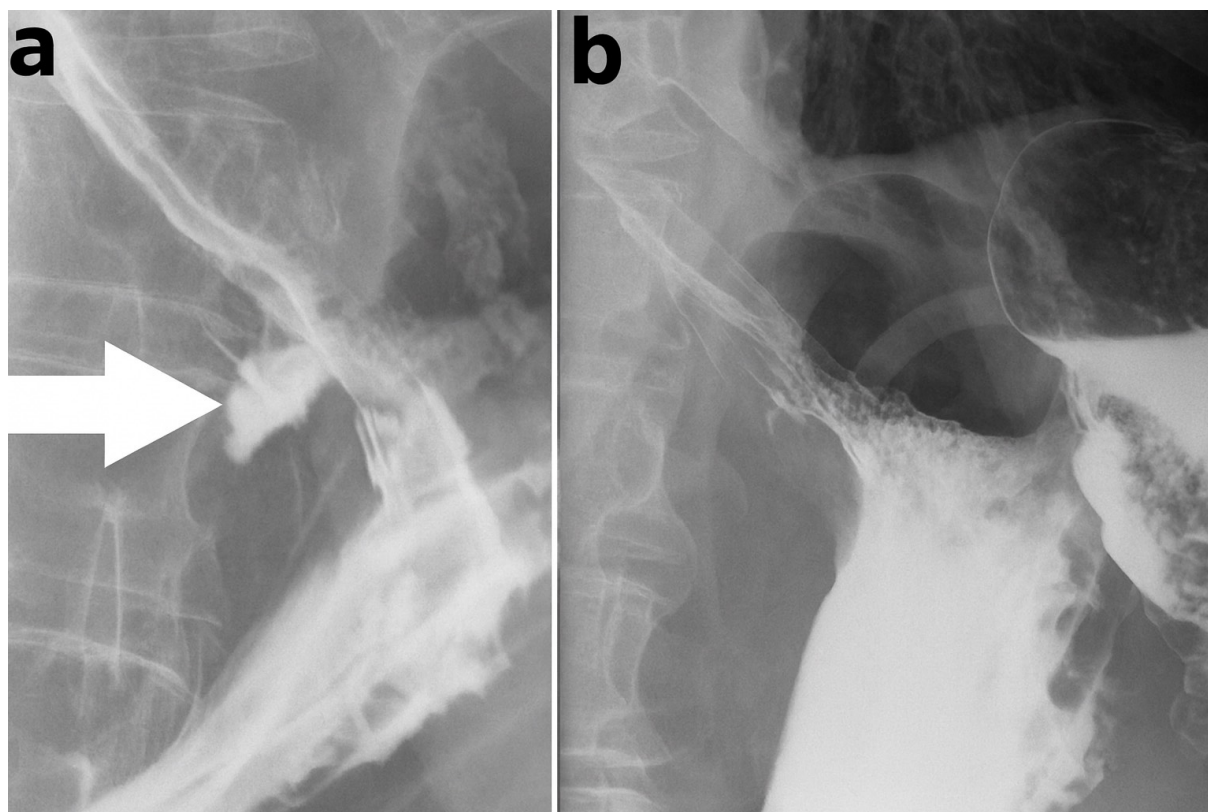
Patient X4. a) X-ray contrast study on 1<sup>st</sup> postoperative day using water-soluble iodine contrast agent showing post-procedure extraluminal and intramural leak in subcardial region (arrow). b) Check-up X-ray contrast study on 10<sup>th</sup> postoperative day showing regression of the finding.
